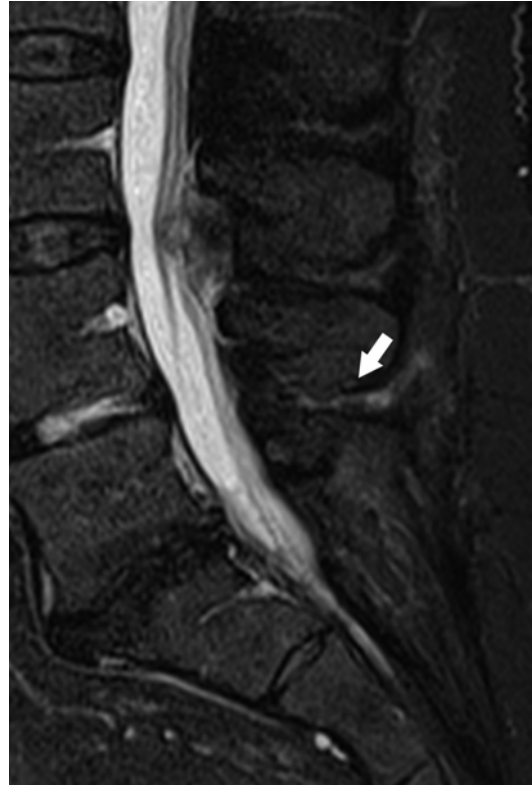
Baastrup disease involving the L4-L5 interspinous space. Fluid within the interspinous space appears hyperintense on sagittal fat-saturated T2 MR images (*arrow*). Note severe L5-S1 disk space narrowing
